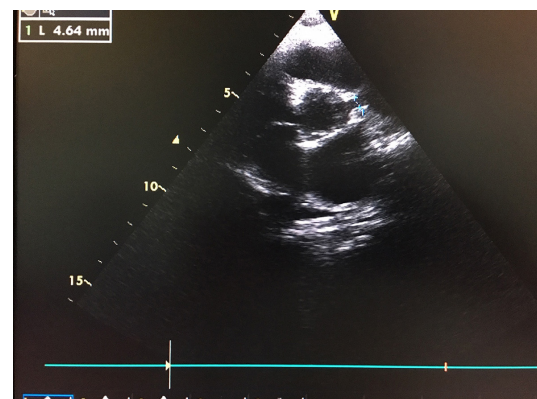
Minimal pericardial effusion in echocardiography of the patient
